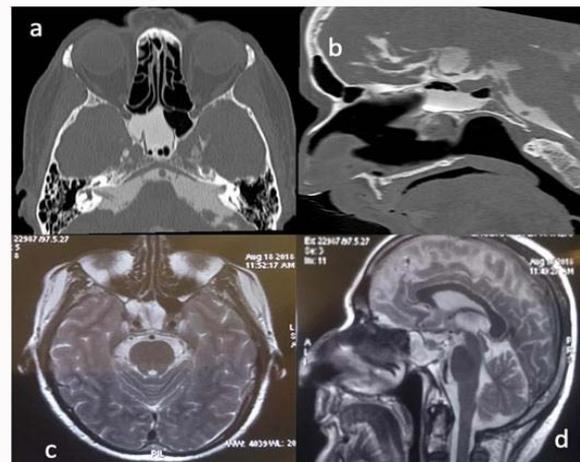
(a) CT cisternography showing right sphenoid sinus filled with CSF and (b) the entry of cerebrospinal fluid into the sphenoid sinus. (c) Axial T2weight MRI revealed right sphenoid sinus filled with CSF. (d) Sagittal T2 MRI shows CSF leakage from preptine cistern to sphenoid sinus.
